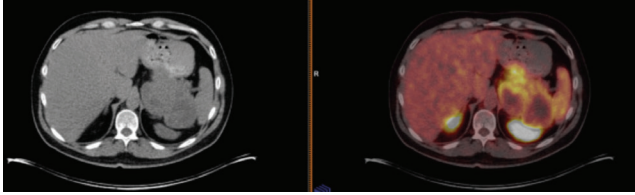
Transaxial images of tumor at CT and PET/CT fusion
